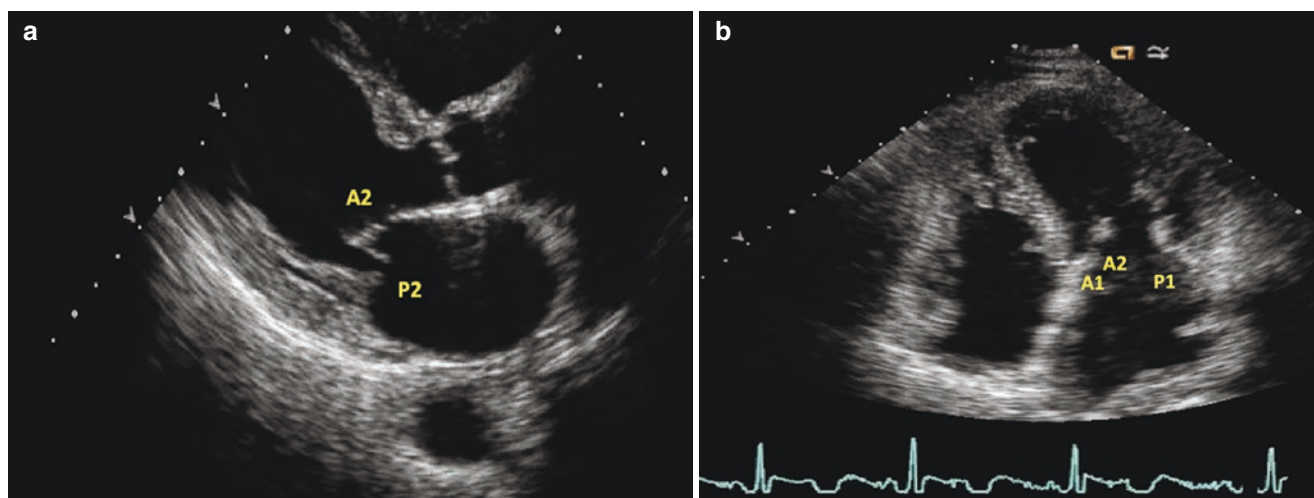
Panel a: Transthoracic parasternal long axis view demonstrating the posterior leaflet prolapse. The scallops at the mitral leaflet tips are A2 and P2. Panel b is an apical four chamber view demonstrating the scallops seen in this view are A1, A2, and P1
